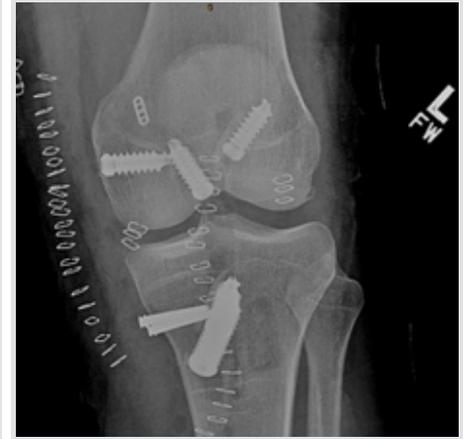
shows immediate post-operative radiographs from a bicruciate plus MCL reconstruction- note the relatively short length of the MCL construct.
